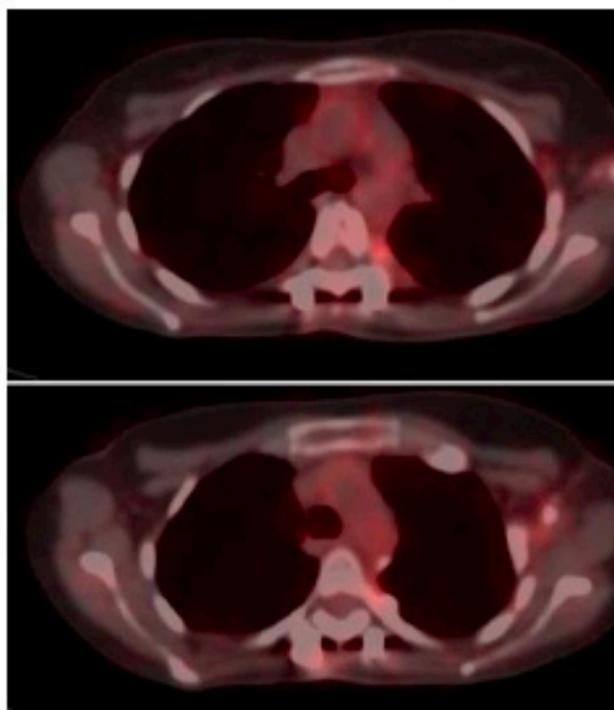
PET-CT images after local radiotherapy and regorafenib treatment.
